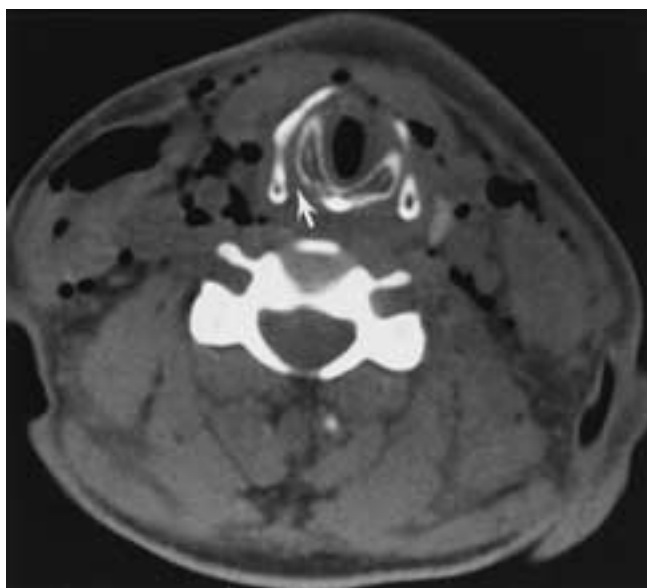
Axial CT shows cricothyroid separation. The cricoid is rotated relative to the thyroid, with widening of the space (*arrow*) between the lower thyroid and the cricoid. Compare with the opposite side.
